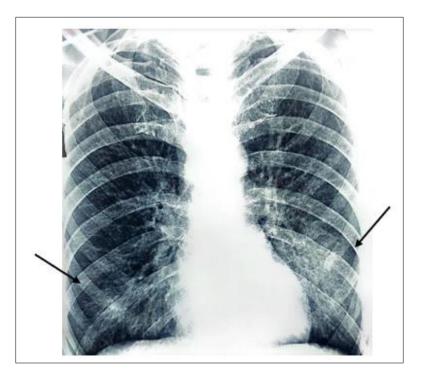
Posteroanterior chest X-ray demonstrating bilateral interstitial syndrome. The image shows diffuse bilateral infiltrative opacities predominantly in the middle and lower lung regions
